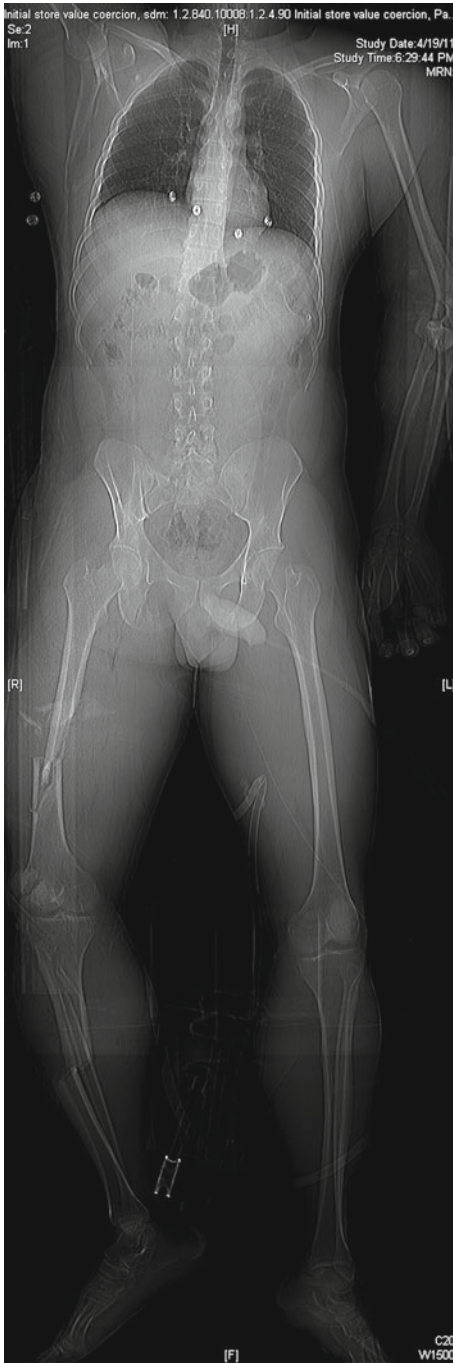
This is a scout film from a CT scan performed on a polytrauma patient. Notice the ipsilateral femoral shaft fracture and tibia fracture or “floating knee.” Also noted on this scout film is a left elbow dislocation
